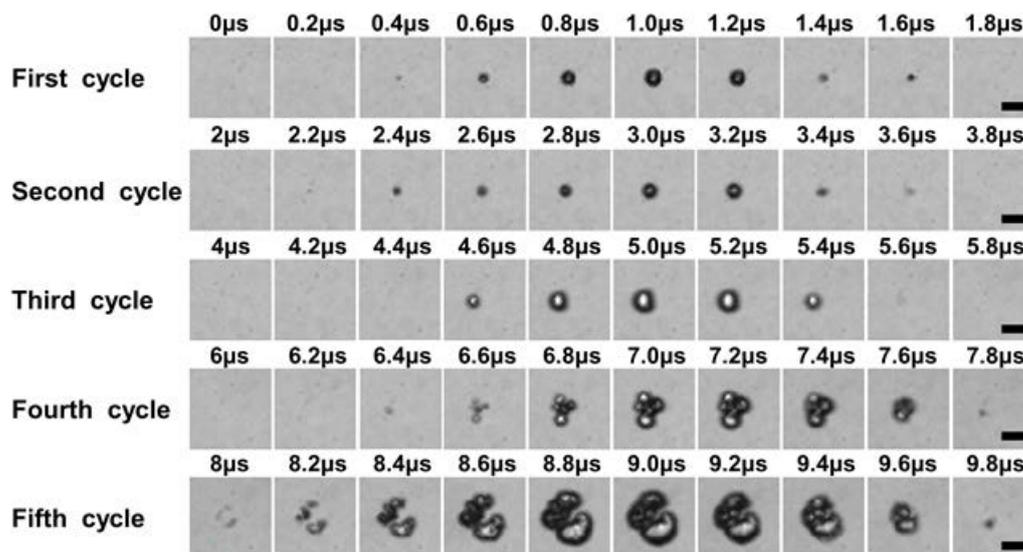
Example of a series of high-speed images of droplet vaporization captured over the first 5 cycles of a 100-cycle ultrasound pulse at 0.5 MHz and peak negative pressure of 1.5 MPa; scale bar is 5 μm . Images were taken at 5 million frames per second with an exposure of 200 ns per frame.
